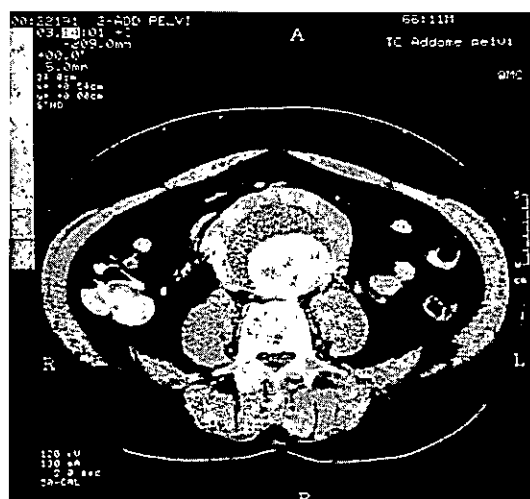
CT scan of a patient with an atherosclerotic IAAA. The peri-aneurysmal fibrosis is present only in the anterior and lateral segments.
